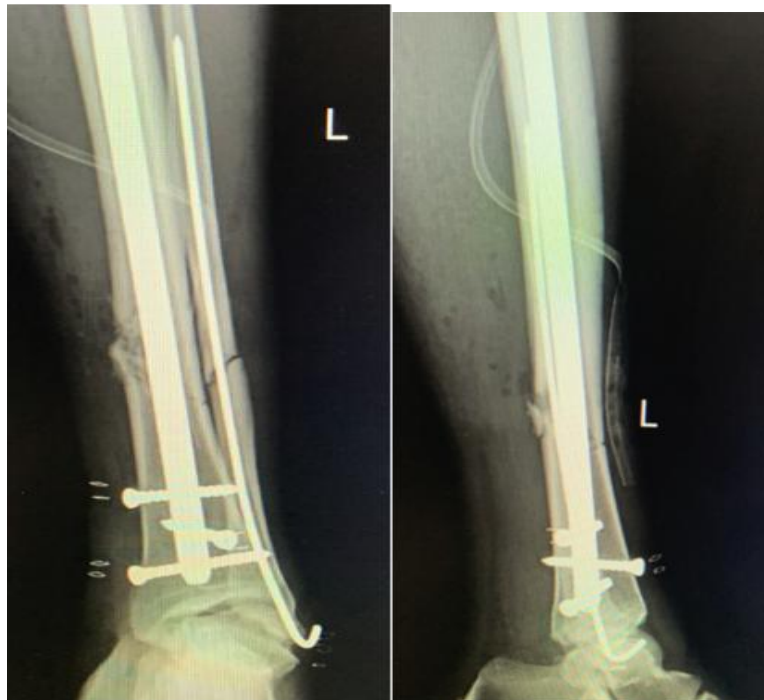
Pre Op X-ray showing incarcerated fragment in the intramedullary canal
